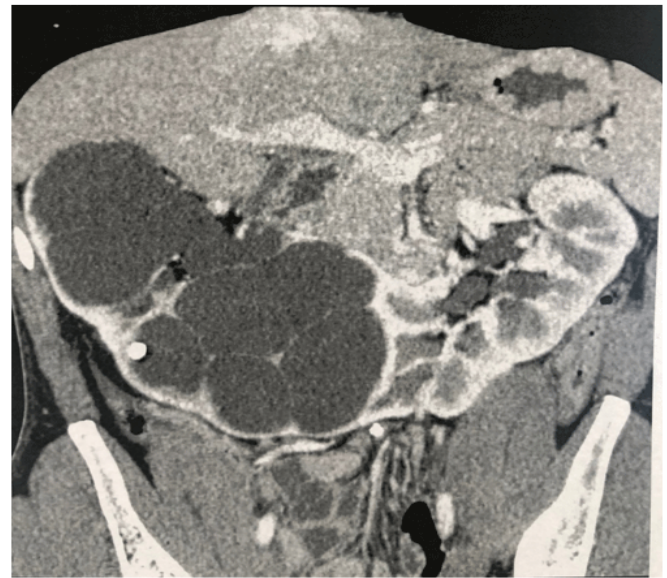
Reconstruct image of the uro-CT showing a horseshoe kidney with a huge dilation of the right kidney
